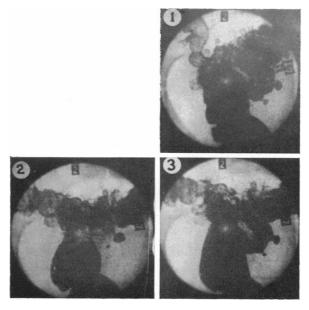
The effect of drugs on diverticula. The two diverticula that are seen in the right lower quadrant of these frames of ciné-radiographic film altered in size in response to drugs. (1) Appearance before morphine. (2) After morphine. (3) After probanthine had reversed the changes wrought by morphine.
